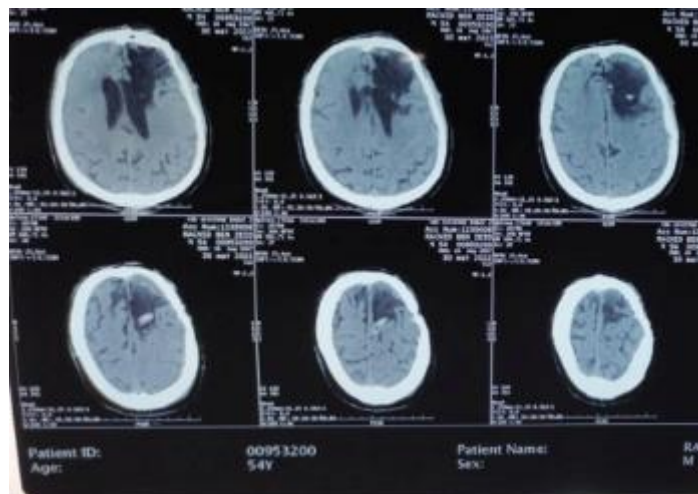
Post-operative CT showed a small cyst in the frontal convexity with reduced size and mass effect
